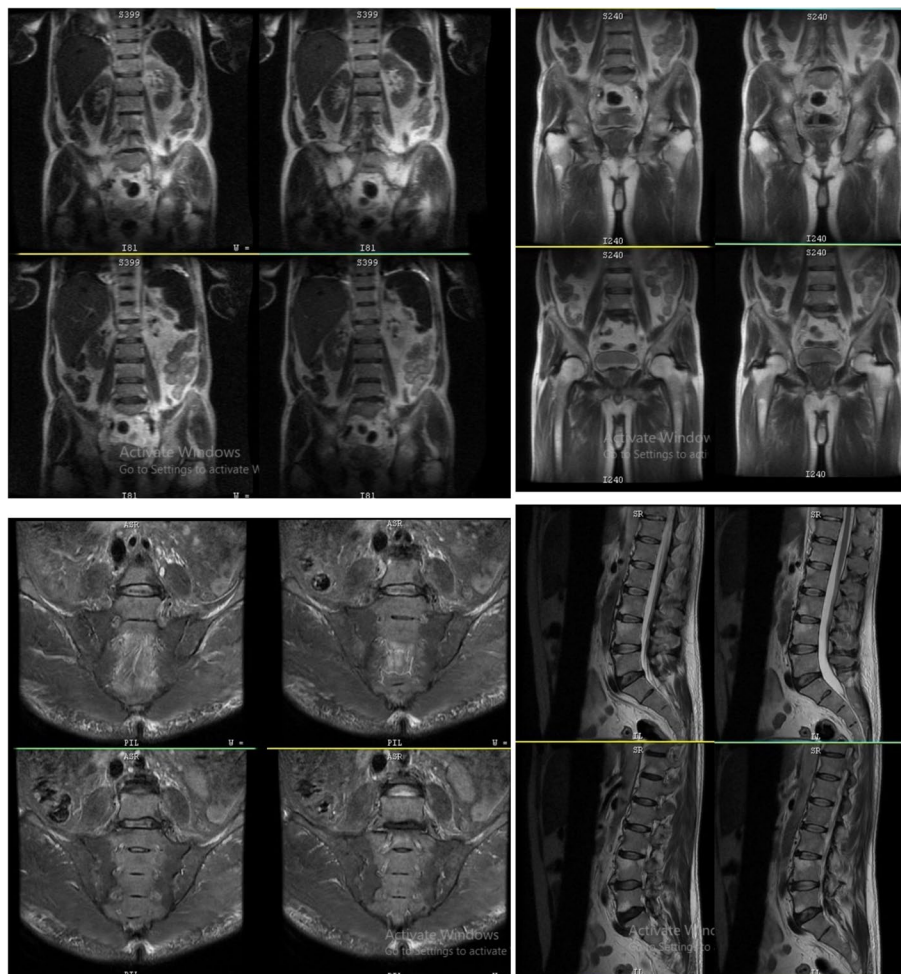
MRI of the lumbar-sacral spine. MRI revealed findings suggestive of the loss of lumbar lordosis and Modic type 2 changes at multiple levels, along with obliteration of the sacroiliac joints (SI Joints) and no active inflammation. The MRI of the lumbar-sacral spine revealed findings suggestive of the loss of lumbar lordosis and Modic type 2 changes at multiple levels, along with obliteration of the sacroiliac joints (SI Joints) and no active inflammation. A hyper-intense signal was observed superior and anterior plates of the L4 and L5 vertebrae and the inferior aspect of the L5 vertebra. These findings indicated Romus and Anderson lesions of ankylosing spondylitis, with ossification of the anterior longitudinal ligament bridging the adjacent upper and lower vertebrae, potentially forming syndesmophytes
